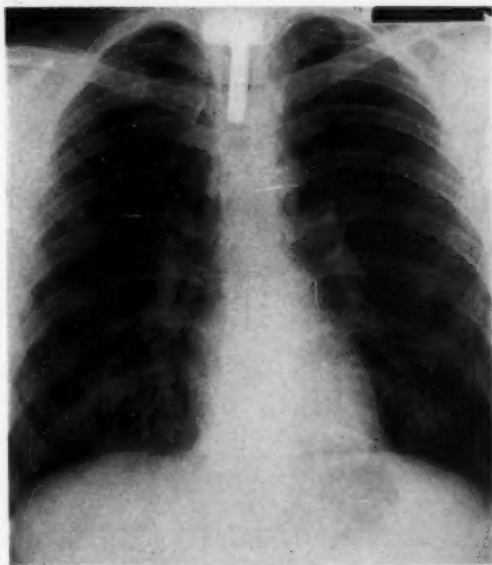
(case 4). Roentgenographic appearance at time of admission to the clinic.
